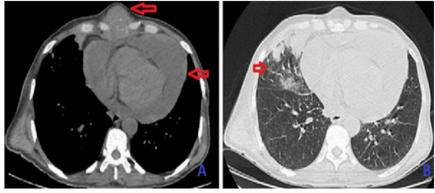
Sagittal CT scan of the thorax
